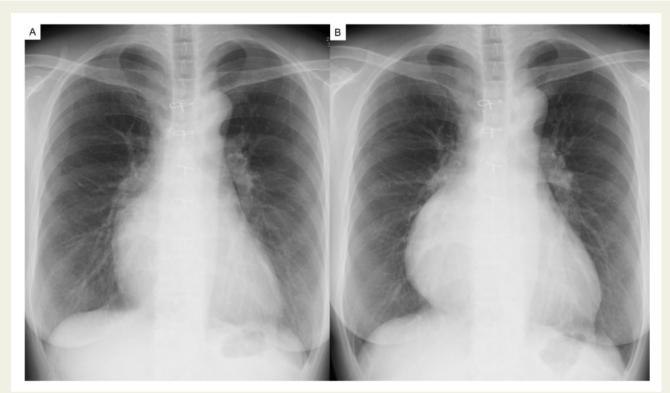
Chest X-rays 3 years prior (A) and on admission (B).
